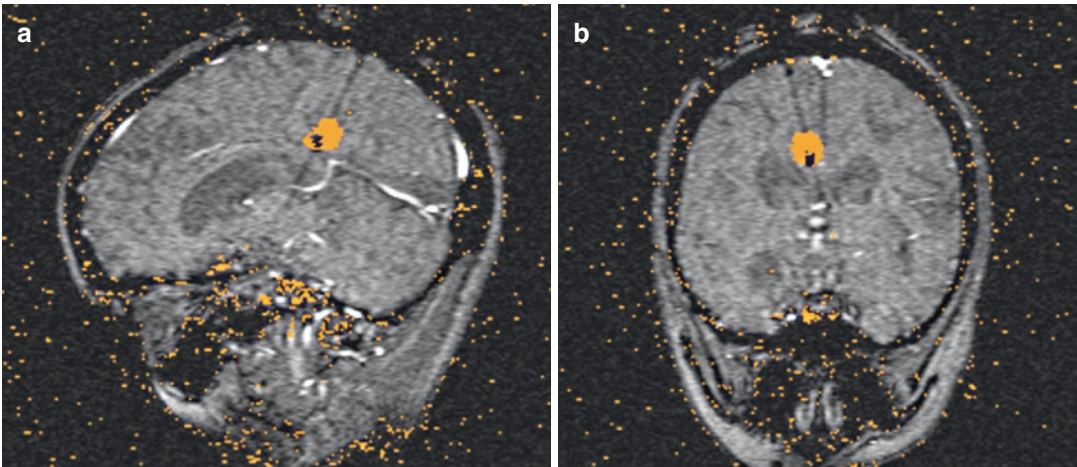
Sagittal (a) and coronal (b) ablation map from MRI thermography demonstrating LITT of a posterior cingulate seizure focus
